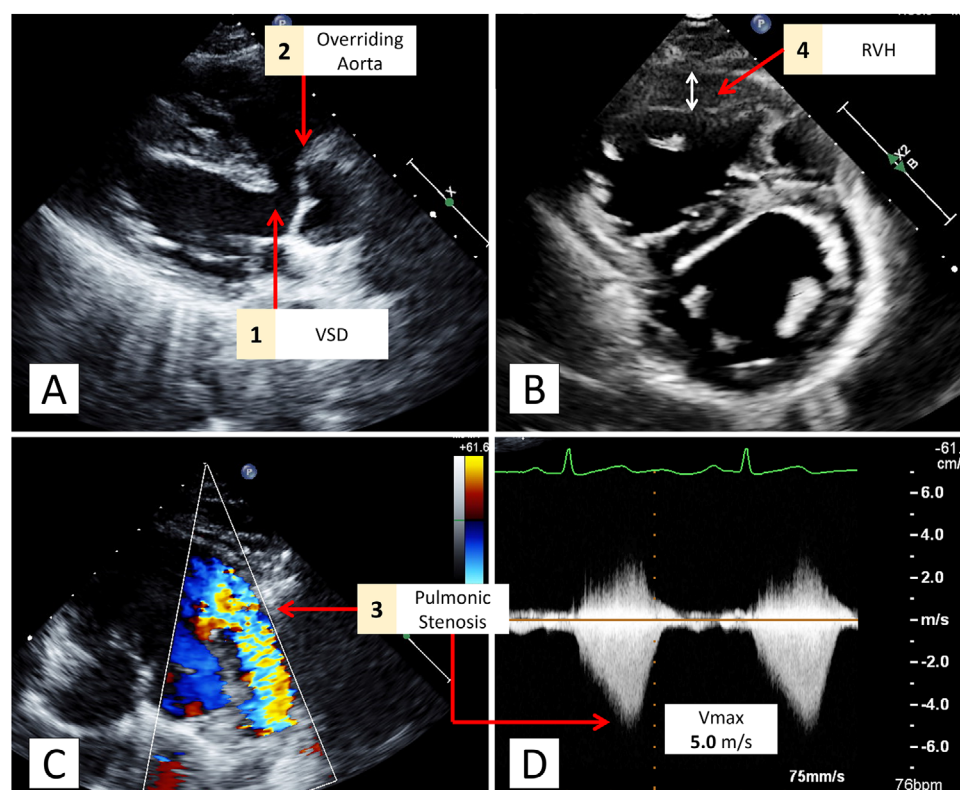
Classic tetrad of unrepaired TOF on TTE Panel A: Parasternal long axis view. Arrow 1 points to a discontinuity in the interventricular septum at the subaortic region. Arrow 2 highlights the overriding of the ascending aorta on the ventricular septal defect. Panel B: Parasternal short-axis view. The double-headed arrow demonstrates increased thickness of the right ventricle due to right ventricular hypertrophy. Panel C: A color Doppler study of the right ventricle outflow highlights aliased velocity and formation of a proximal isovelocity convergence zone (arrow 3) at the level of the pulmonic valve, consistent with significant stenosis. Panel D: Spectral Doppler study of the right ventricular outflow tract at the same level as Panel C shows a peak velocity of roughly 5 m/s, confirming severe pulmonary stenosis. The increased density and late peaking shape of the jet are additional signs of severe obstruction. RVH, right ventricular hypertrophy; VSD, ventricular septal defect.
